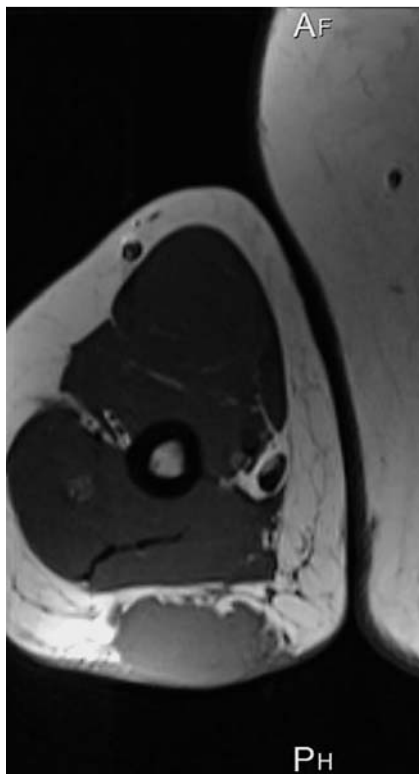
MRI of the right arm. Tumor infiltration in subcutaneous tissue.
